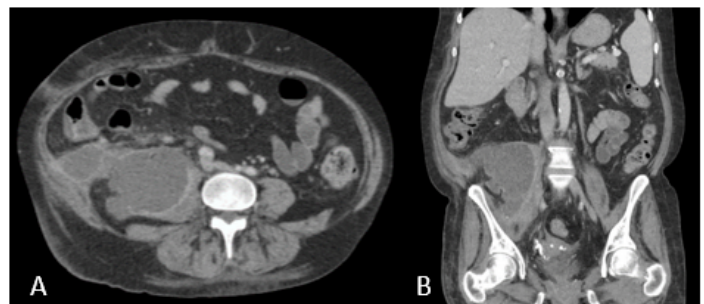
Axial (A) and coronal (B) slices from a computed tomography scan obtained during the patient's November 2021 hospitalization demonstrating a right psoas abscess.
